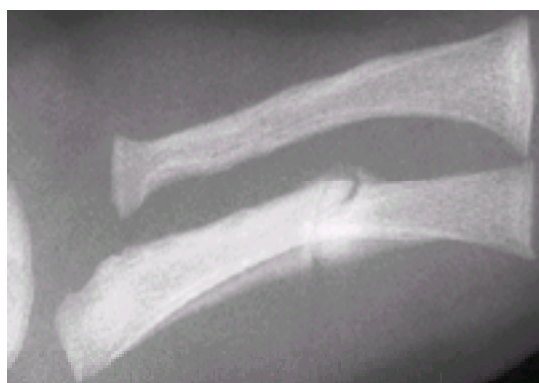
Radiograph of the left forearm of a 3-month-old victim of child abuse. Although the ulnar fracture is transverse and thus by itself is not diagnostic of intentional injury, both the child's age and the extent of periosteal bone formation (again establishing a significant delay between diagnosis and medical evaluation) should strongly suggest the possibility of child abuse to the examining physician.
